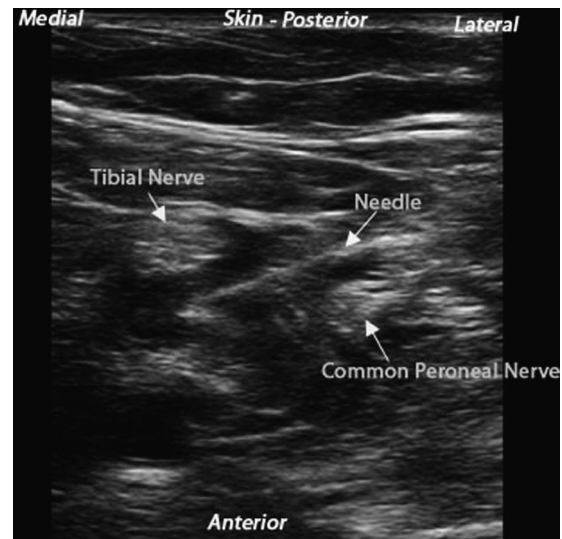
Ultrasound scan of the tibial and common peroneal nerves in the popliteal fossa, 3 cm distal to sciatic nerve bifurcation. Note the needle position between the 2 nerves and the local anesthetic spread.
